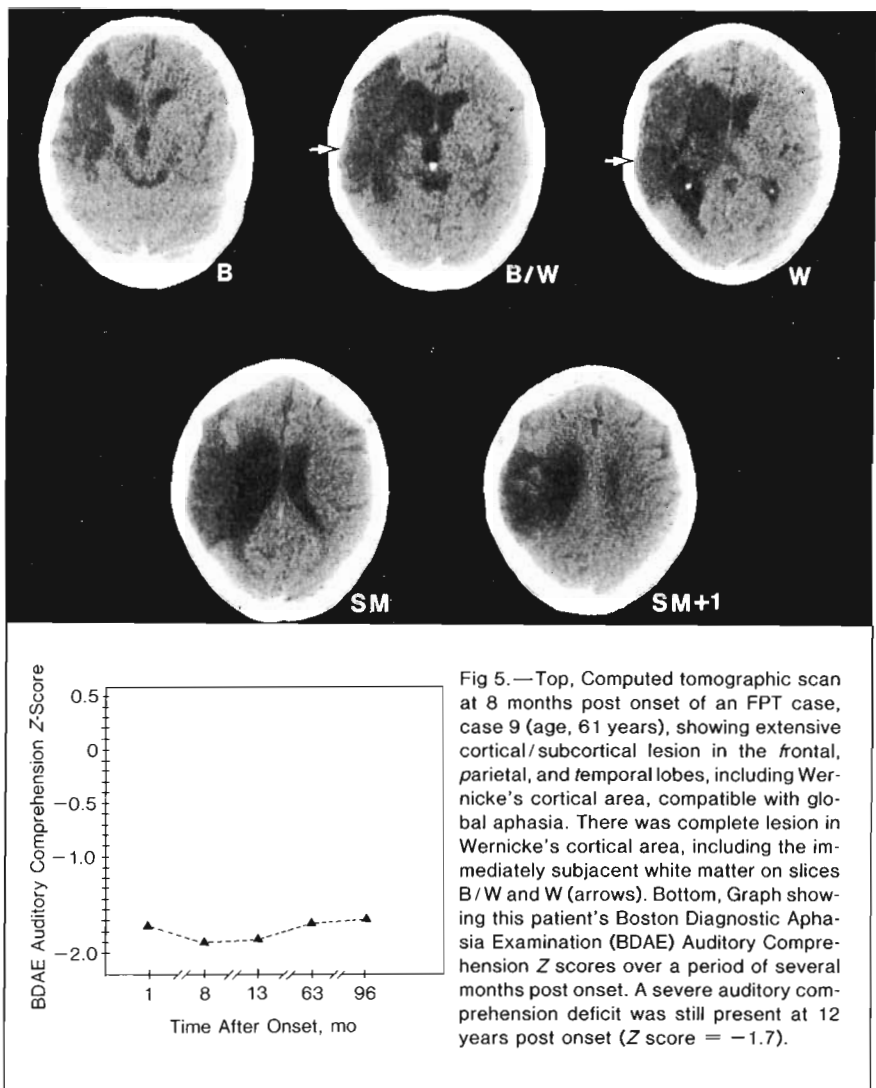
Top, Computed tomographic scan at 8 months post onset of an FPT case, case 9 (age, 61 years), showing extensive cortical/subcortical lesion in the frontal, parietal, and temporal lobes, including Wernicke's cortical area, compatible with global aphasia. There was complete lesion in Wernicke's cortical area, including the immediately subjacent white matter on slices B/W and W (arrows). Bottom, Graph showing this patient's Boston Diagnostic Aphasia Examination (BDAE) Auditory Comprehension Z scores over a period of several months post onset. A severe auditory comprehension deficit was still present at 12 years post onset (Z score = -1.7).
